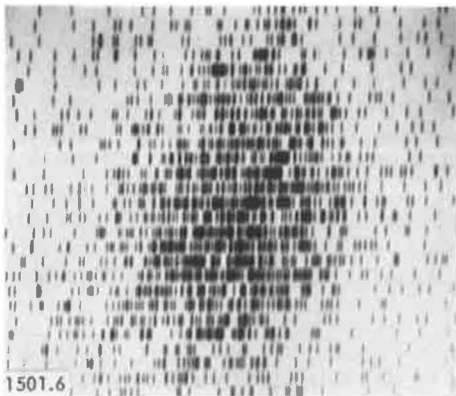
Right hemithyroidectomy. Visualization of thyroid by the conventional scintigram method is poor
